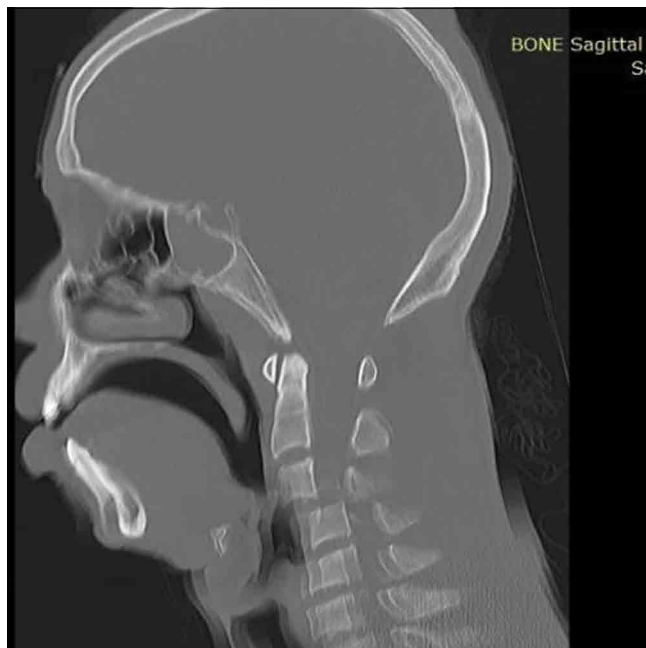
Cervical spine CT sagittal bone window showing C3 on C4 anterior subluxation.
